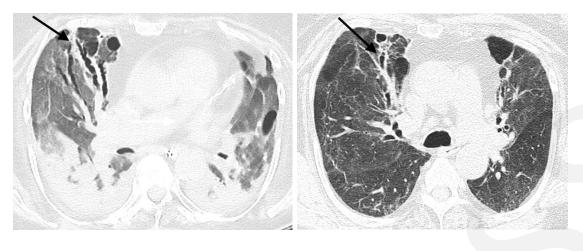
56-year-old man with fibrosis resulting from SARS-CoV-2 infection. (A)Contrast-enhanced axial CT image early during infection shows extensive ground glass opacity with posterior and peripheral predominant consolidation and some areas of crazy-paving. (B) Unenhanced axial CT image from 10 months later shows lower lobe predominant reticulation, traction bronchiectasis, and ground glass opacity with lower lobe volume loss.
